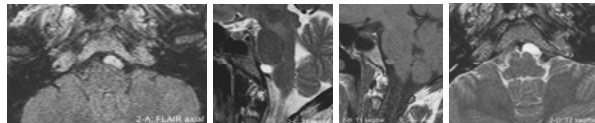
Cystic, extra-axial, approximately 1.2 x 0.5 cm ovoid lesion at the pontomedullary junction, to the left of the midline. Distinctly hyperintense signal in T2WI (C, sagittal; D, axial) and the FLAIR sequence (A, axial). Moderately hyperintense in T1WI (B, sagittal) compared to CSF.
